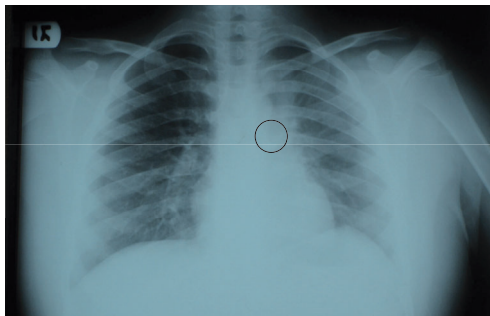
Posterior/anterior chest X-ray showing location of tooth (circled) in the left main bronchus
